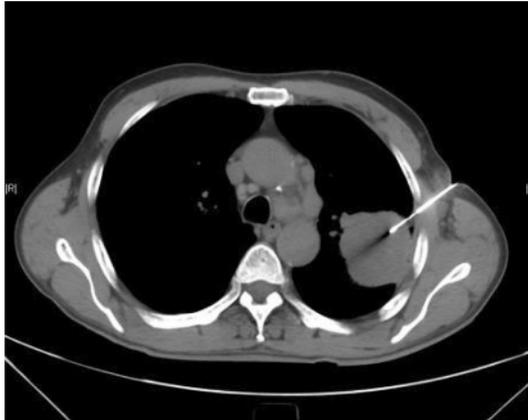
CT-guided percutaneous biopsy
